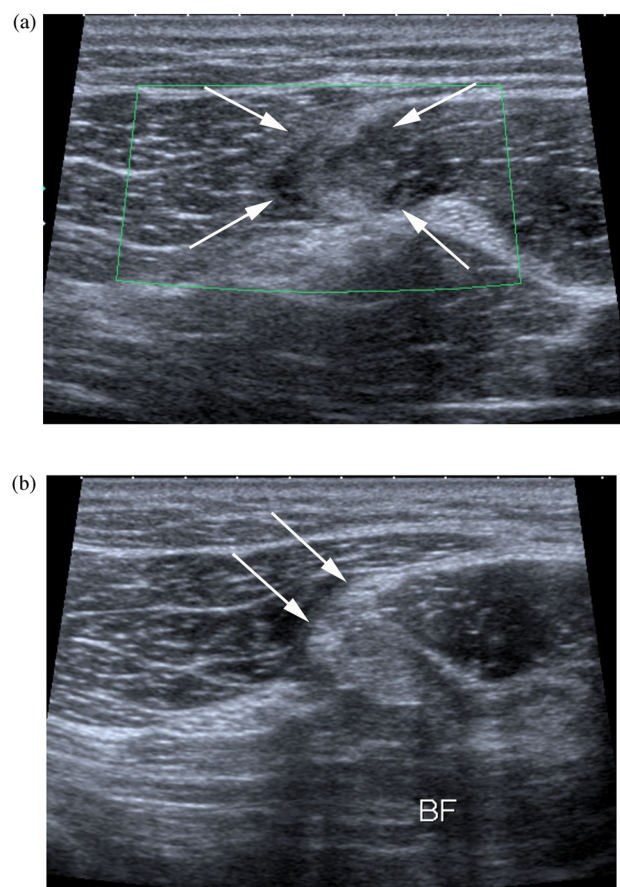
(A) Ultrasound-detected grade 3C injury at the proximal myo-tendinous junction of the long head of the biceps femoris muscle in a 21-year-old male sprinter. Partial disruption of the intramuscular tendon is depicted (arrows), exhibiting ill-defined margins, hypoechogenicity and focal central thinning consistent with focal partial discontinuity. (B) A normal ultrasound appearance of the tendon in another elite athlete for comparison, exhibiting well-defined margins and high echogenicity, with preserved thickness at the proximal myotendinous junction (arrows). (A and B) Transverse views.
